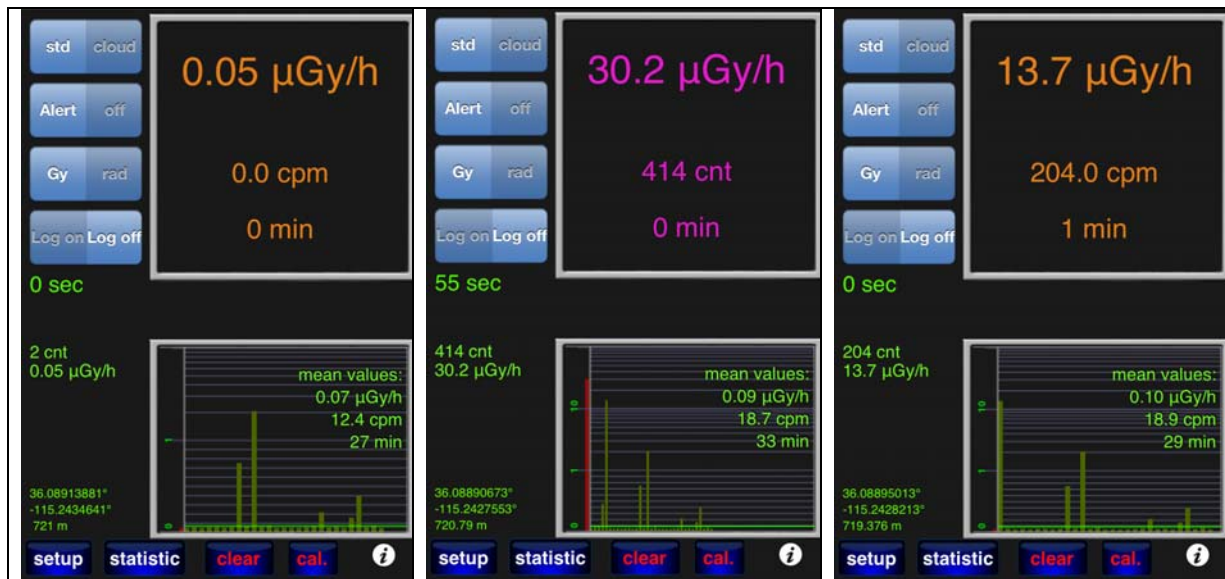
Smartphone showing dose rate for a) background situation, b) with a running X-ray source on the radiologists body without wearing protective shielding and c) with the same position and for the same condition as in b) but with RadPad protective shielding.
